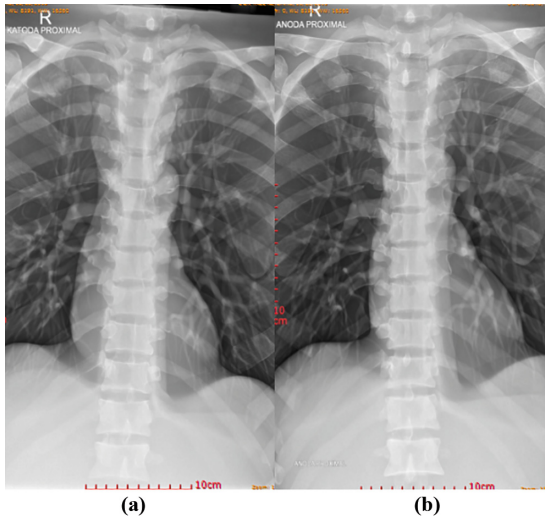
Results of the AP projection radiograph (a) the distal part is at the cathode (b) the proximal part is at the cathode
